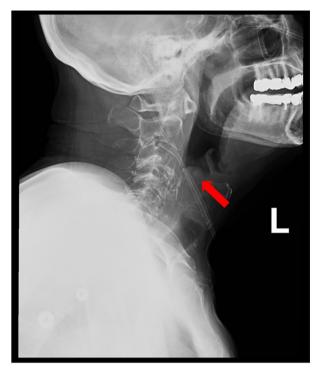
A lateral soft-tissue X-ray of the neck was obtained after initial chest X-ray was negative. The lateral film was read as equivocal, with possible thickening of the arylepiglottic folds (arrow).
